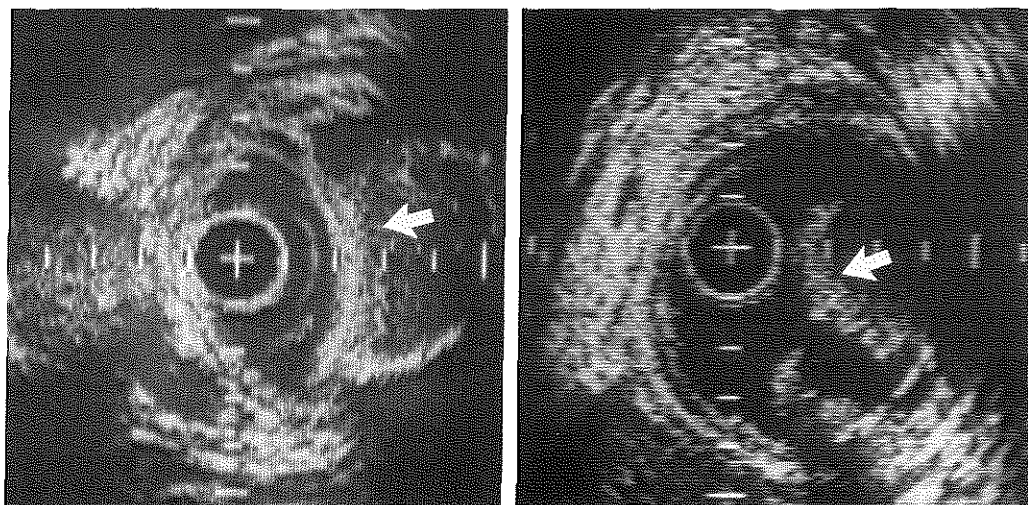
Intravascular ultrasound cross sections obtained from two patients after balloon angioplasty revealing a large intimal flap (arrow) beyond which no reliable echo data can be obtained. Calibration = 1 mm.
